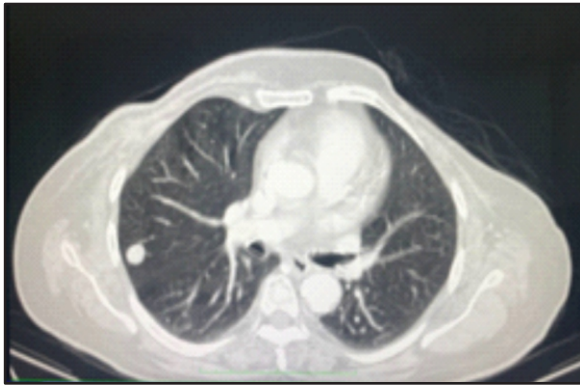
CT thorax showing 12 x 11 mm STO lesion in posterior segment of RUL
